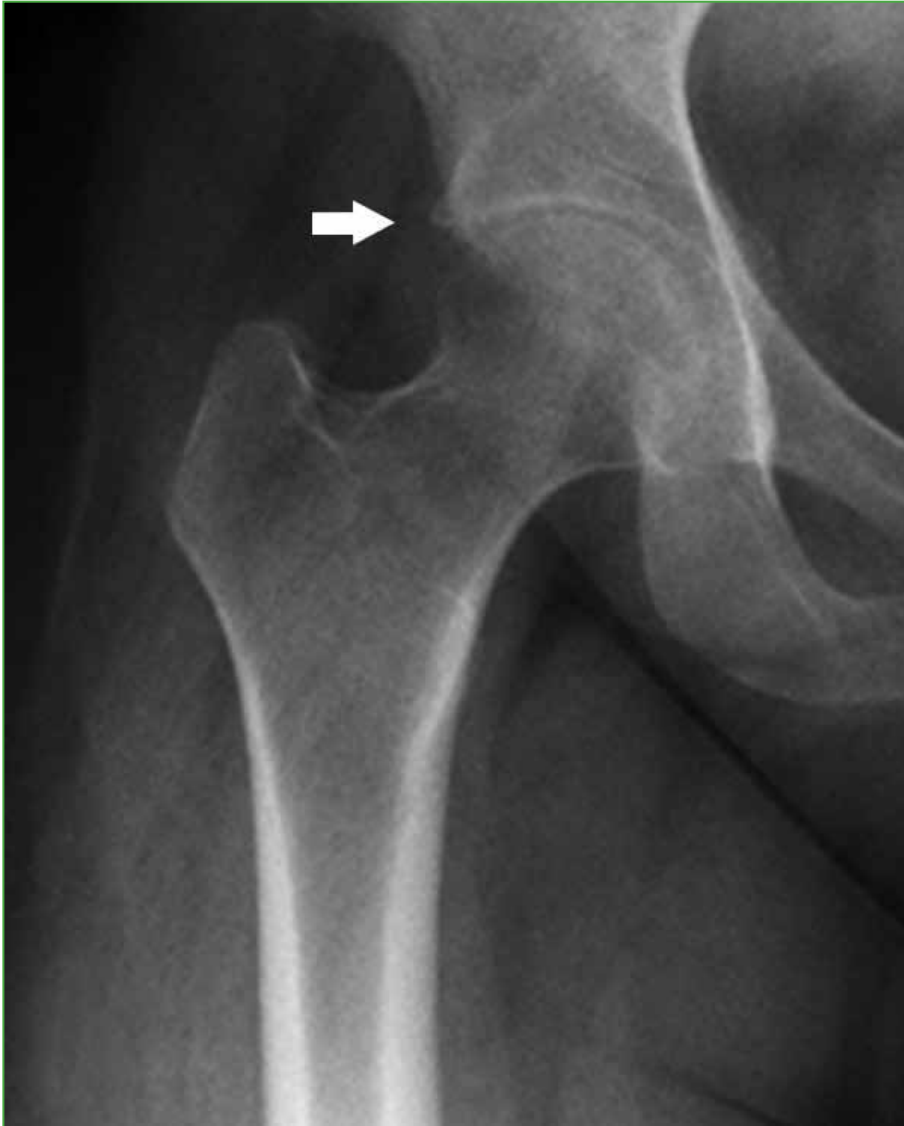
Right hip radiograph. Incipient arthritic changes with acetabular overcoverage are visualized. No soft tissue lesions are observed.
